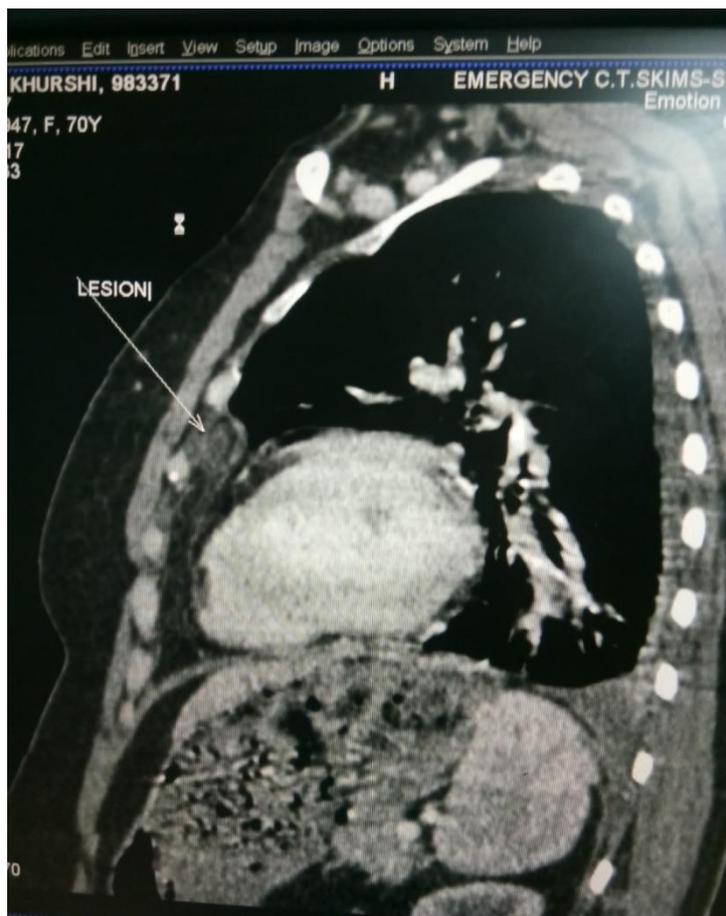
Sagittal CT images revealing well defined fat containing lesion with central heterogeneity overlying pericardium suggestive of encapsulated pericardial fat necrosis.
